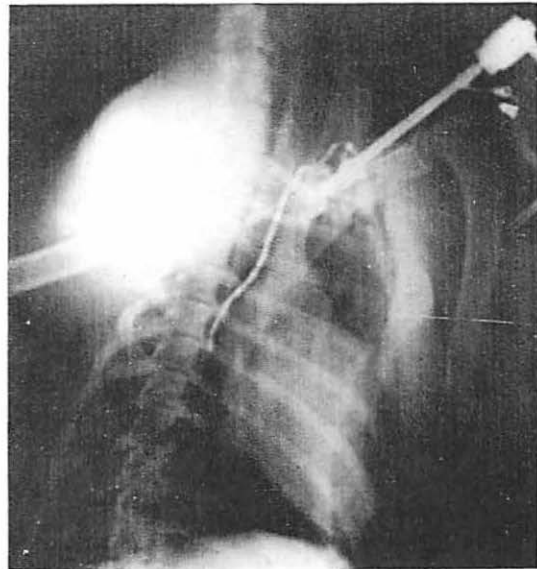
X-ray showing retrograde filling with Angio-Conray® of the thoracic duct, preterminal lymph cistern and a cervical lymph node via Dyonics needle-scope. See Fig. 1, T 14.
